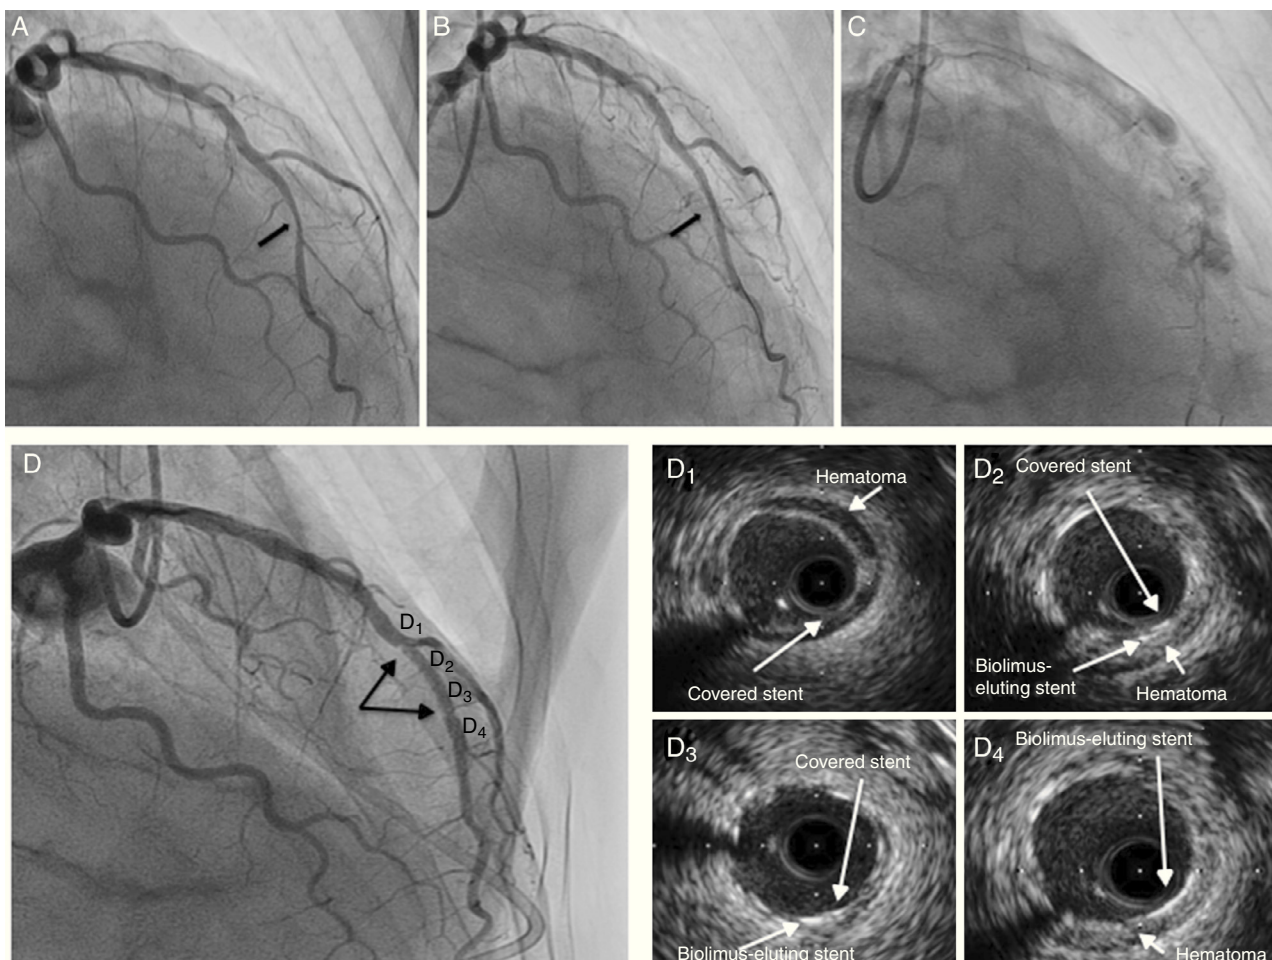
(A) Coronary angiography (right anterior oblique view) showing a severe lesion in the mid left anterior descending artery (arrow); (B) underexpanded biolimus-eluting stent (arrow); (C) coronary artery perforation after postdilatation with non-compliant balloon; (D) coronary angiography after hemodynamic stabilization showing probable underexpansion of the covered stent (arrows); (D1–4) intravascular ultrasound after postdilatation with non-compliant balloon: (D1) segment with a well-expanded covered stent and hematoma outside the lumen; (D2 and 3) segment with two layers of stent (covered stent and biolimus-eluting stent); (D4) segment with a biolimus-eluting stent only.
